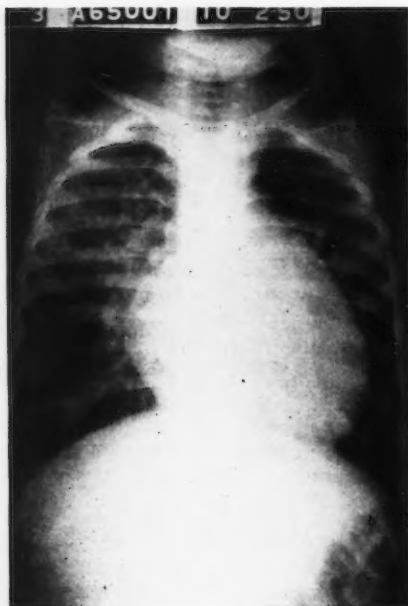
X-rays of chest, patent ductus arteriosus. Patient C. U., case 7, anterior-posterior, October, 1950. Cardiothoracic ratio 62.5 per cent. Note large pulmonary arteries and vascular appearing lung fields.
